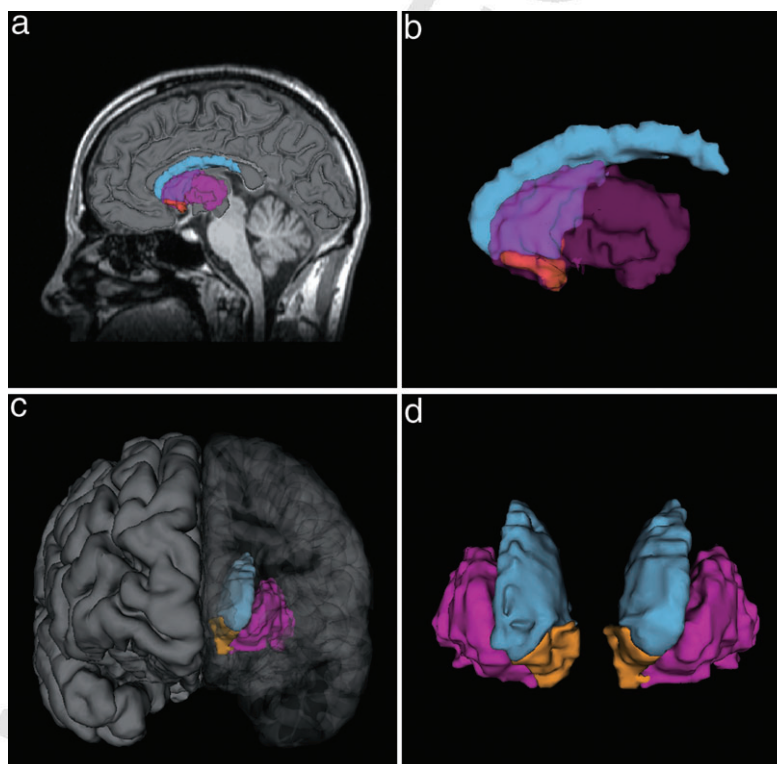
Three-dimensional model of the human brain indicating the position of the striatal nuclei. (a) Sagittal view of the model superimposed on the magnetic resonance imaging image of head (c) anterior view. Magnified images showing only striatal structures in the sagittal (b) and anterior (d) views, respectively. Caudate is indicated in blue, putamen in pink and nucleus accumbens area in yellow
